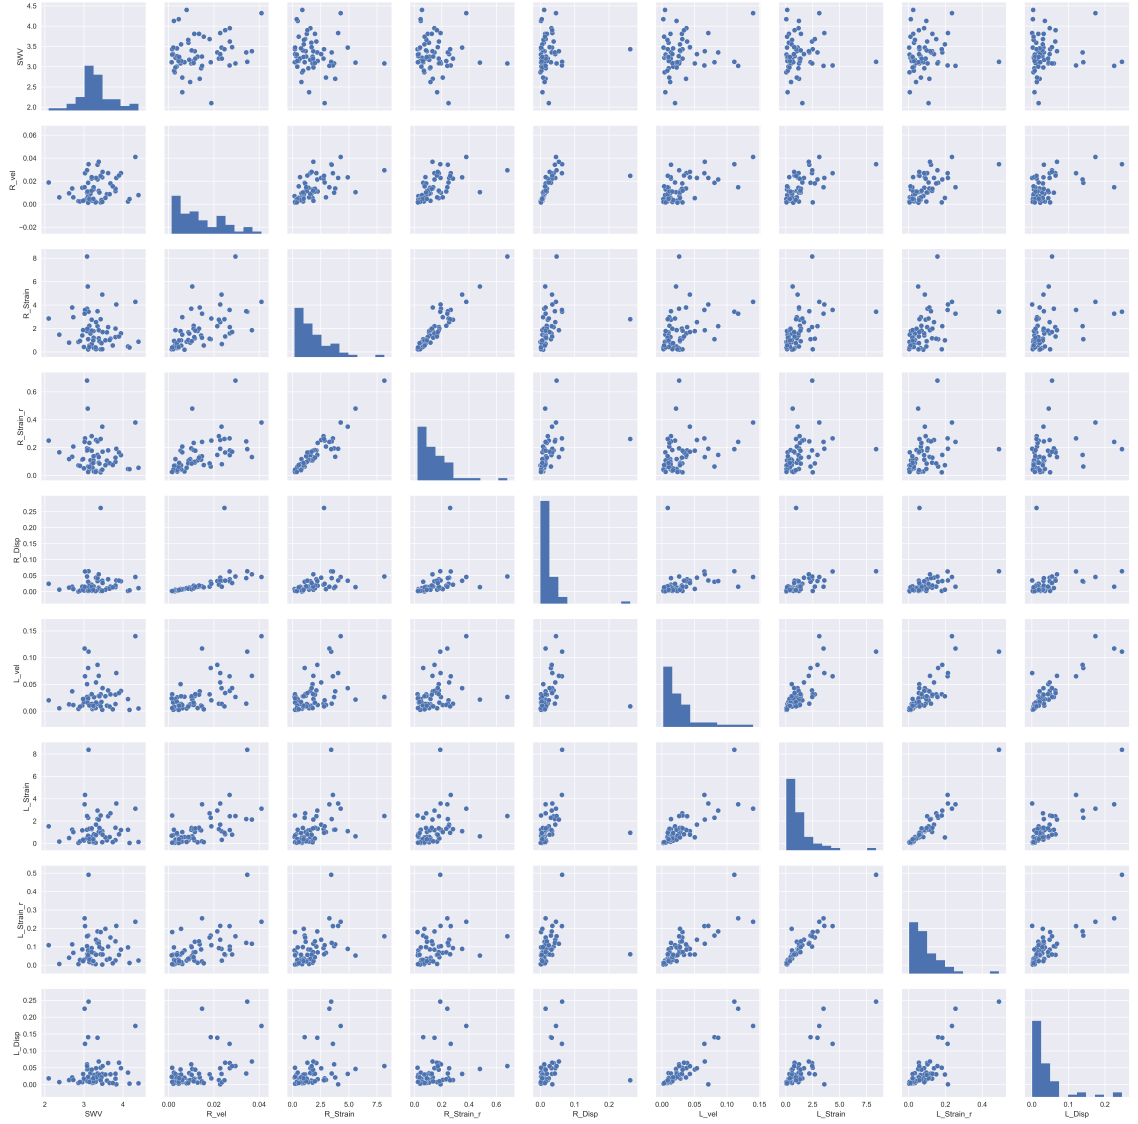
Pairwise scatterplots visualising relationships between ultrasound measurements from VVI and SWE all US variables assessed. A number of linear correlations are clear in the data, such as between radial strain, and radial strain rate. Other pairs such as shear wave velocity and radial strain rate show no association
